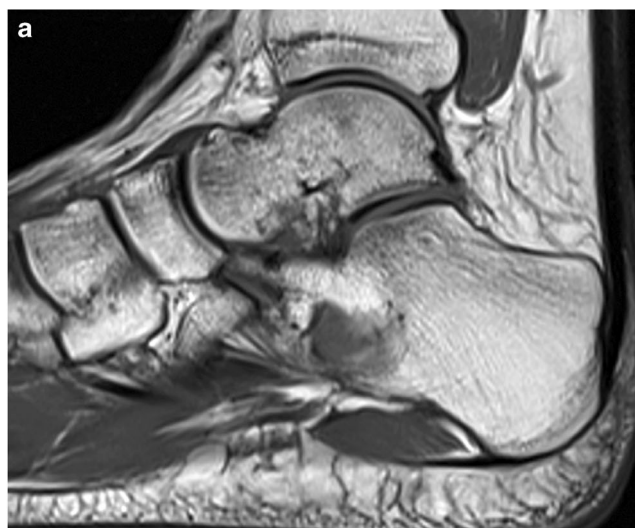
Sagittal T1-weighted MRI images respectively 4 (a) and 7 (b) years after initial examination: the low signal intensity of the cystic area is gradually replaced by a high signal intensity similar to subcutaneous fat signal
